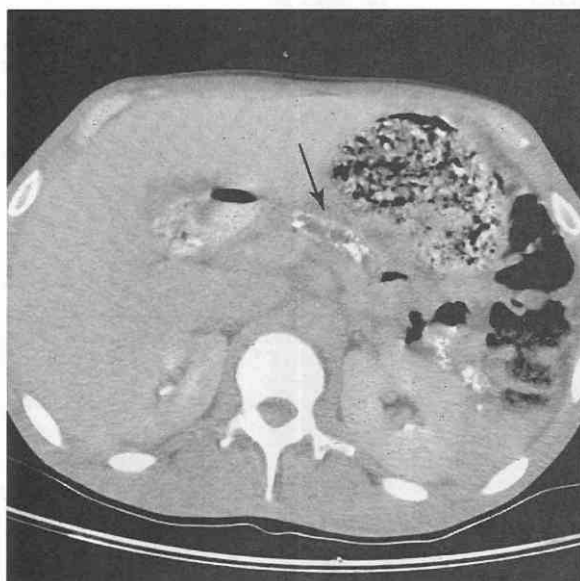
CT scan shows dilatation of pancreatic duct with calcifications in the wall (arrow).
